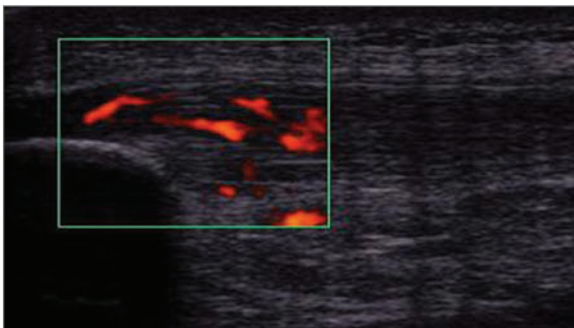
Preinjection: Power Doppler demonstrating extensive neovascularity within the proximal patellar tendon.
